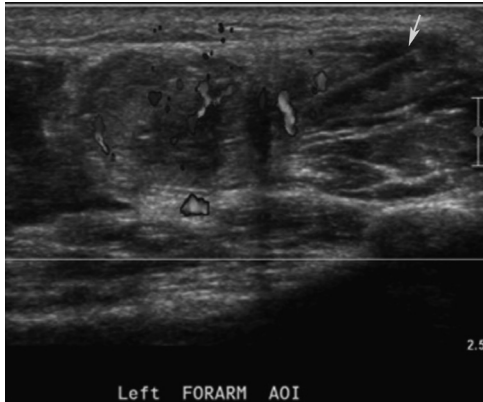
Ultrasound image with Doppler demonstrates the hyperechoic foreign body (*arrow*) with surrounding hyperemia. This was consistent with a palm frond and was not seen with plain radiographs.
